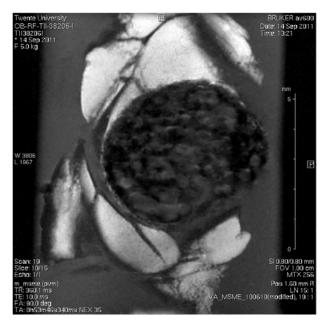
T1-weighted image of a SN, surrounded by fat tissue. The image was acquired using a multi-slice-multi-echo (MSME) sequence.
